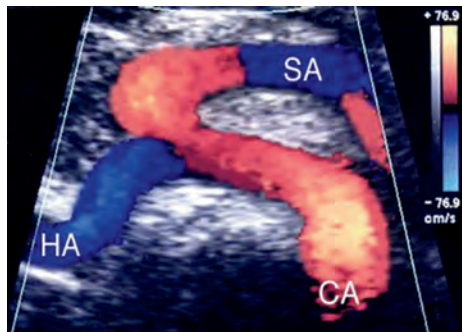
Celiac artery (CA)—i.e., celiac trunk—with branches. The hepatic artery (HA) takes blood to the liver; the splenic artery (SA) takes blood to the spleen. All Doppler flow is low-resistance because organs have a constant need for blood supply. Courtesy of Steve Bernhardt, BS, RDMS, RVT, RPhS.
